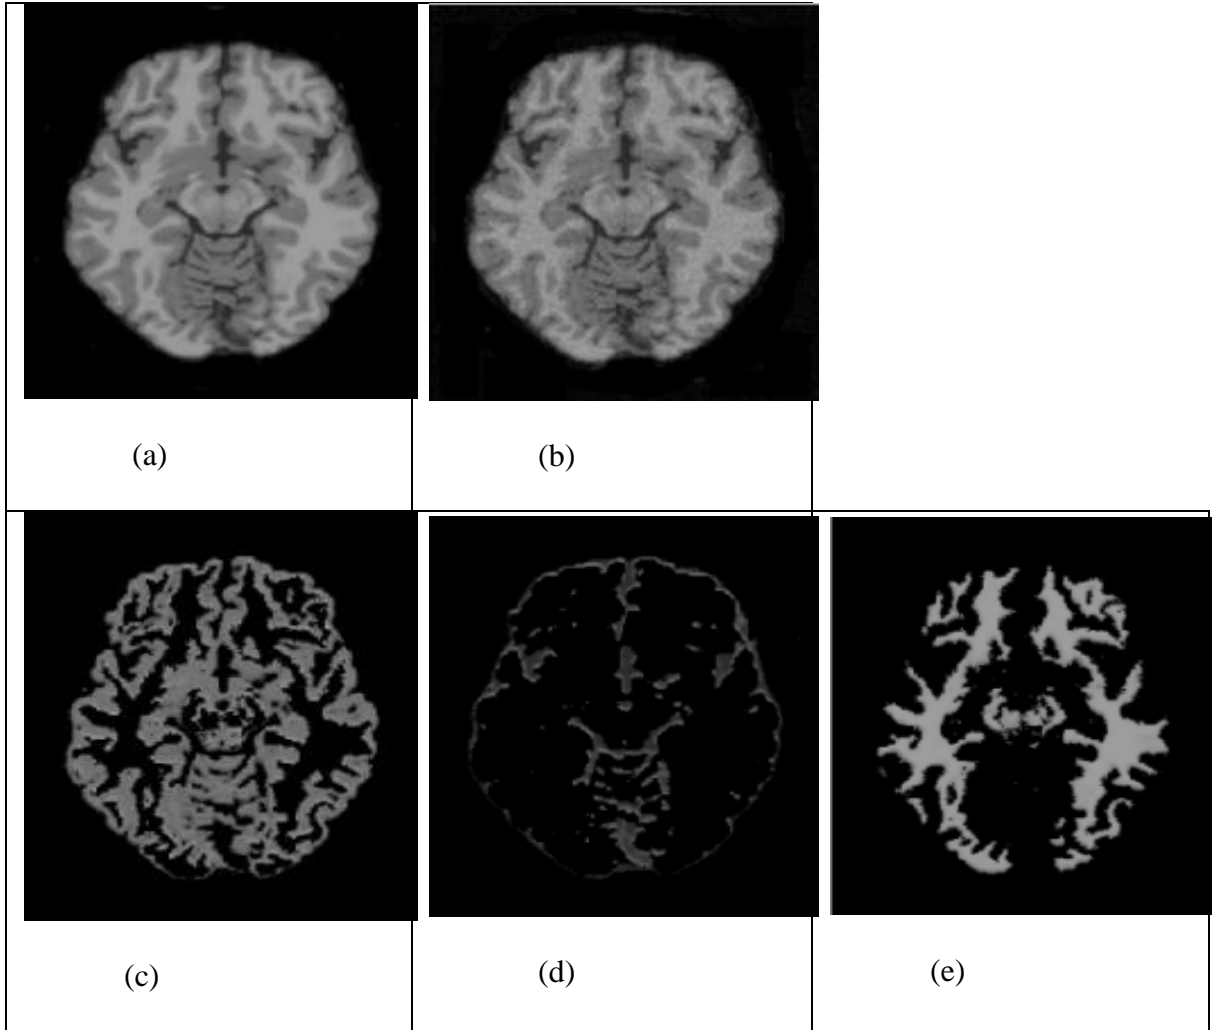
(a) Normal Brain(T1-weighted slice 60), (b) Normal brain (noise 3%), (c) Gray matter, (d) CSF, (e) White matter
